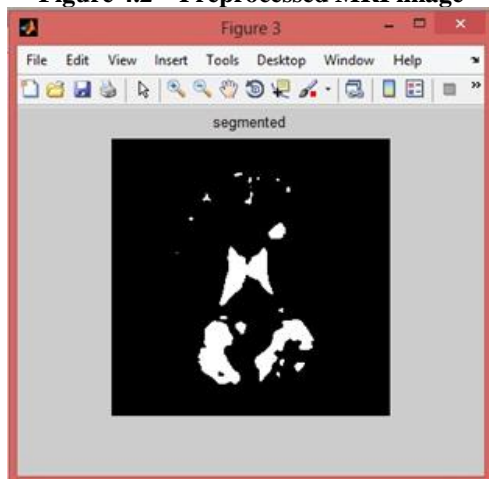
Segmented MRI image
